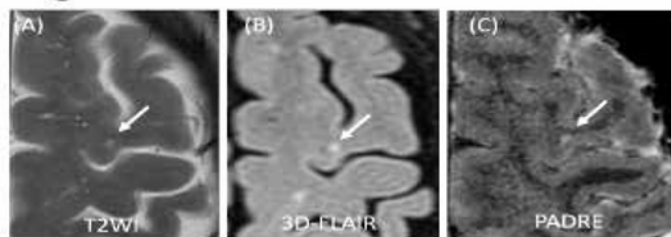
Figure caption An example of a small juxtacortical lesion which also involves the GM. At the first reading session, two neuroradiologists judged the small lesion as not involving the GM; they could not say convincingly that the lesion involved the GM because of almost no contrasts between the GM and subcortical WM on T2WI (A) and 3D FLAIR (B). At the second reading session with PADRE image (C), however, they judged the lesion as involving the GM. Because PADRE offers very clear contrast between the GM and subcortical WM, even a subtle involvement of the GM might be easily identified.
